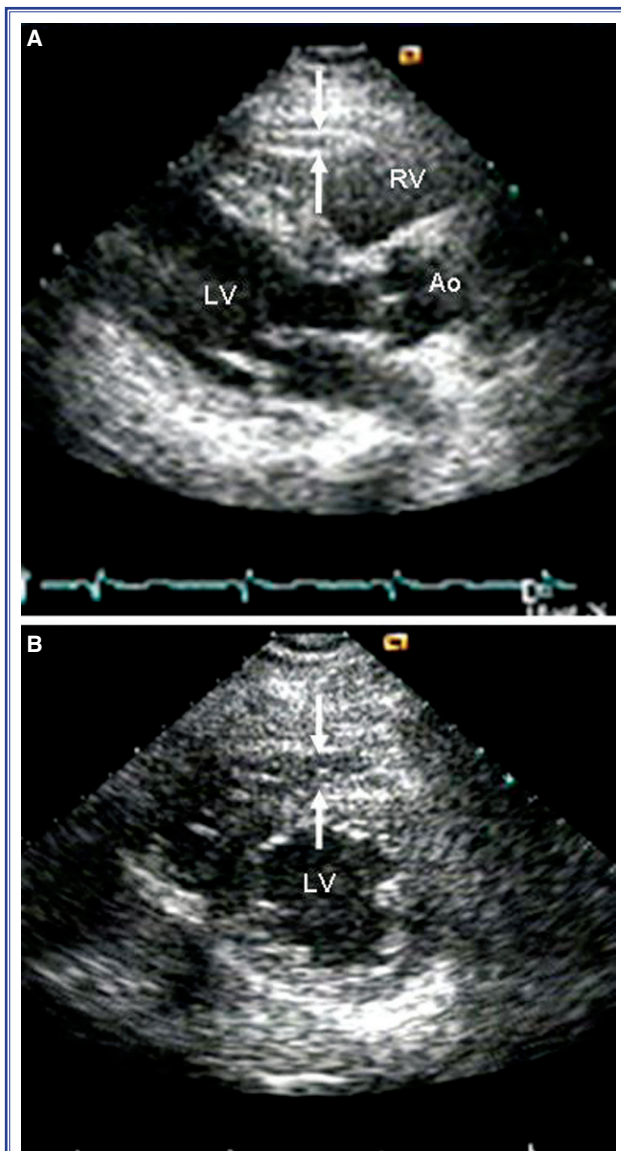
Epicardial adipose tissue in transthoracic 2-dimensional echocardiography in parasternal (A) long and (B) short axis views.
